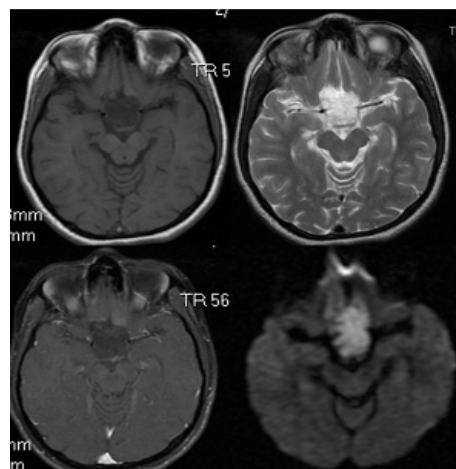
A known case of suprasellar epidermoid lesion appearing hypointense on axial T1W and hyperintense on T2W images, not enhancing on the post contrast images. DWI shows restricted diffusion.
